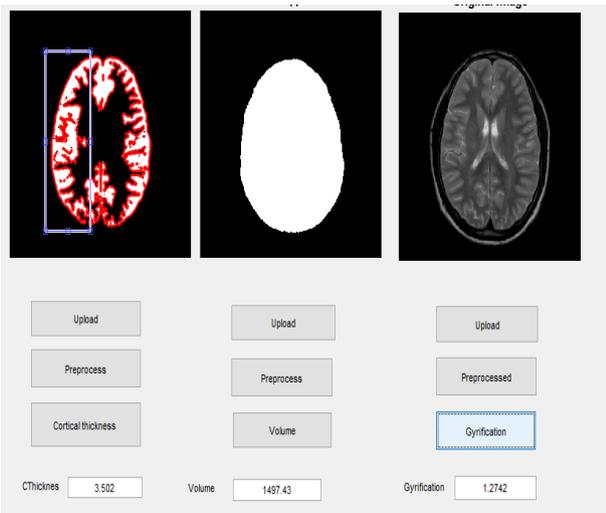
Selected MRI after the preprocessing region-based segmentation algorithm used to segmented Morphological parameters.
